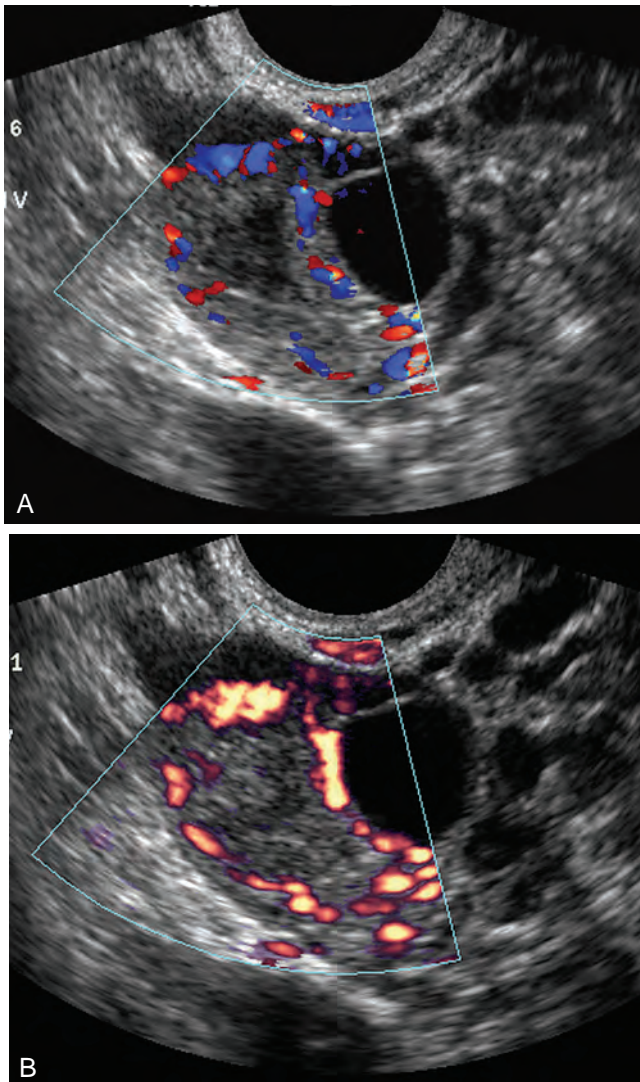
Color Doppler (A) and power Doppler (B). Power Doppler estimates the power or strength of the Doppler signal rather than the mean frequency shift. Although the Doppler detection sequence used in power Doppler is the same as that used in frequency-based color Doppler, once the Doppler shift has been detected, the frequency components are ignored in lieu of the total energy of the Doppler signal. The color and hue relate to the moving blood volume rather than to the direction or the velocity of flow.
